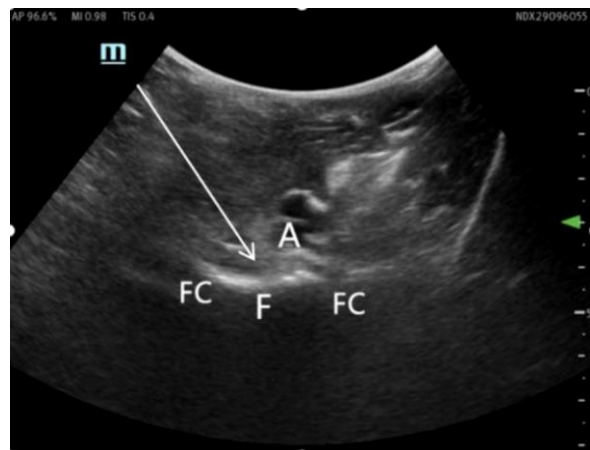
Ultrasound-Guided Infiltration Between the Popliteal Artery and Capsule of the Posterior Knee Block
